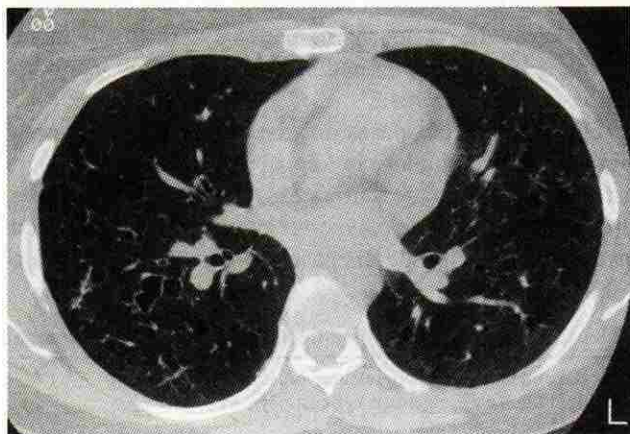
Computed tomogram of patient with pulmonary Langerhans cell histiocytosis. Note thin-walled cysts throughout both lungs. The cysts are slightly more irregular than the characteristic spherical mass cysts of lymphangioleiomyomatosis (Figure 9). Also distinct is the upper lung distribution seen with pulmonary Langerhans cell histiocytosis.
